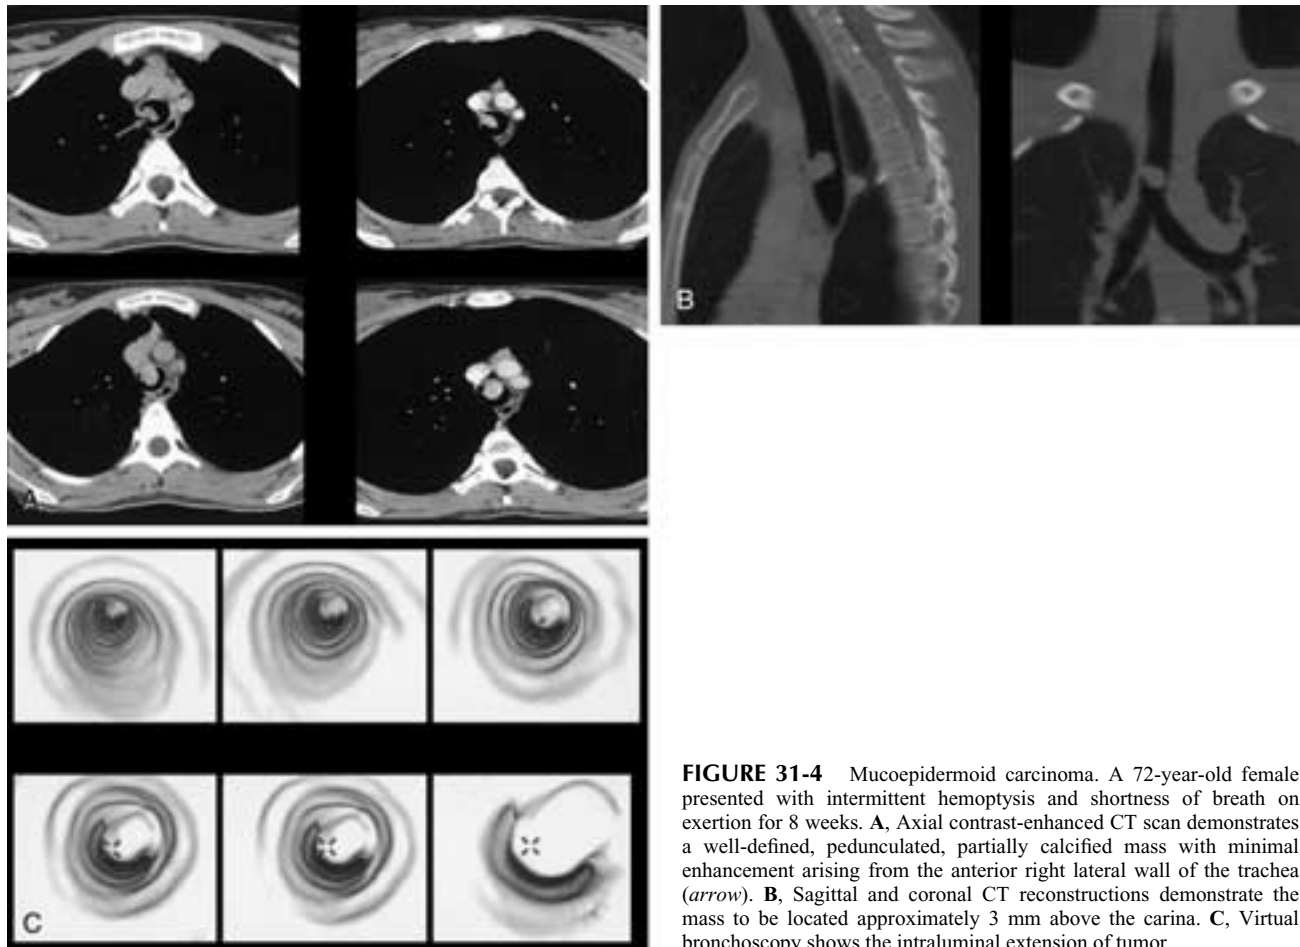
Mucoepidermoid carcinoma. A 72-year-old female presented with intermittent hemoptysis and shortness of breath on exertion for 8 weeks. A, Axial contrast-enhanced CT scan demonstrates a well-defined, pedunculated, partially calcified mass with minimal enhancement arising from the anterior right lateral wall of the trachea (*arrow*). B, Sagittal and coronal CT reconstructions demonstrate the mass to be located approximately 3 mm above the carina. C, Virtual bronchoscopy shows the intraluminal extension of tumor.
